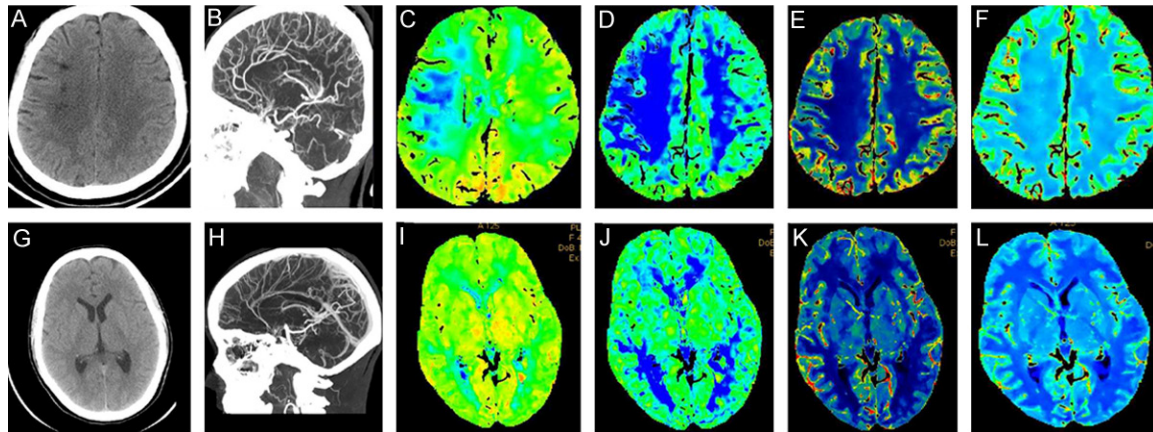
A-F were from the same patient with ischemic MD. G-L were from the same patient with hemorrhagic MD. A: Plain CT. a few patchy hypoperfusions were found at the right prefrontal cortex; B: MIP. Opening of posterior choroidal artery and dorsal pericallosal artery; C: TTP. TTP increased at the right prefrontal lobe; D: MTT. MTT increased at the right prefrontal lobe; E: CBF. Blood flow reduced at the right prefrontal lobe; F: CBV. Blood volume slightly reduced at the right prefrontal lobe. G: Plain CT one year after hemorrhage and the hemorrhagic focus was completely absorbed; H: MIP. Opening of posterior choroidal artery and dorsal pericallosal artery; I: TTP. TTP decreased at the left basal ganglia region; J: MTT. MTT decreased at the left basal ganglia region; K: CBF. Blood flow increased at the left temporal lobe; L: CBV. Blood volume slightly increased at the left temporal lobe.
